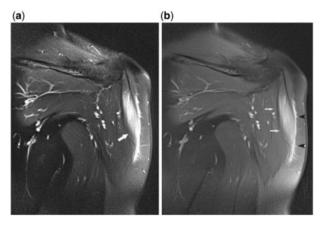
MR images in a 56-year-old woman with COVID-19 vaccine-related painful myopathy. (a) Coronal T2-weighted MR image with fat saturation shows diffuse edema infiltrating the deltoid muscle (arrows), as well as adjacent perifascial fluid (arrowheads). (b) Coronal T1-weighted MR image with fat saturation after gadolinium administration reveals intense focal enhancement of affected deltoid muscle (arrow).
